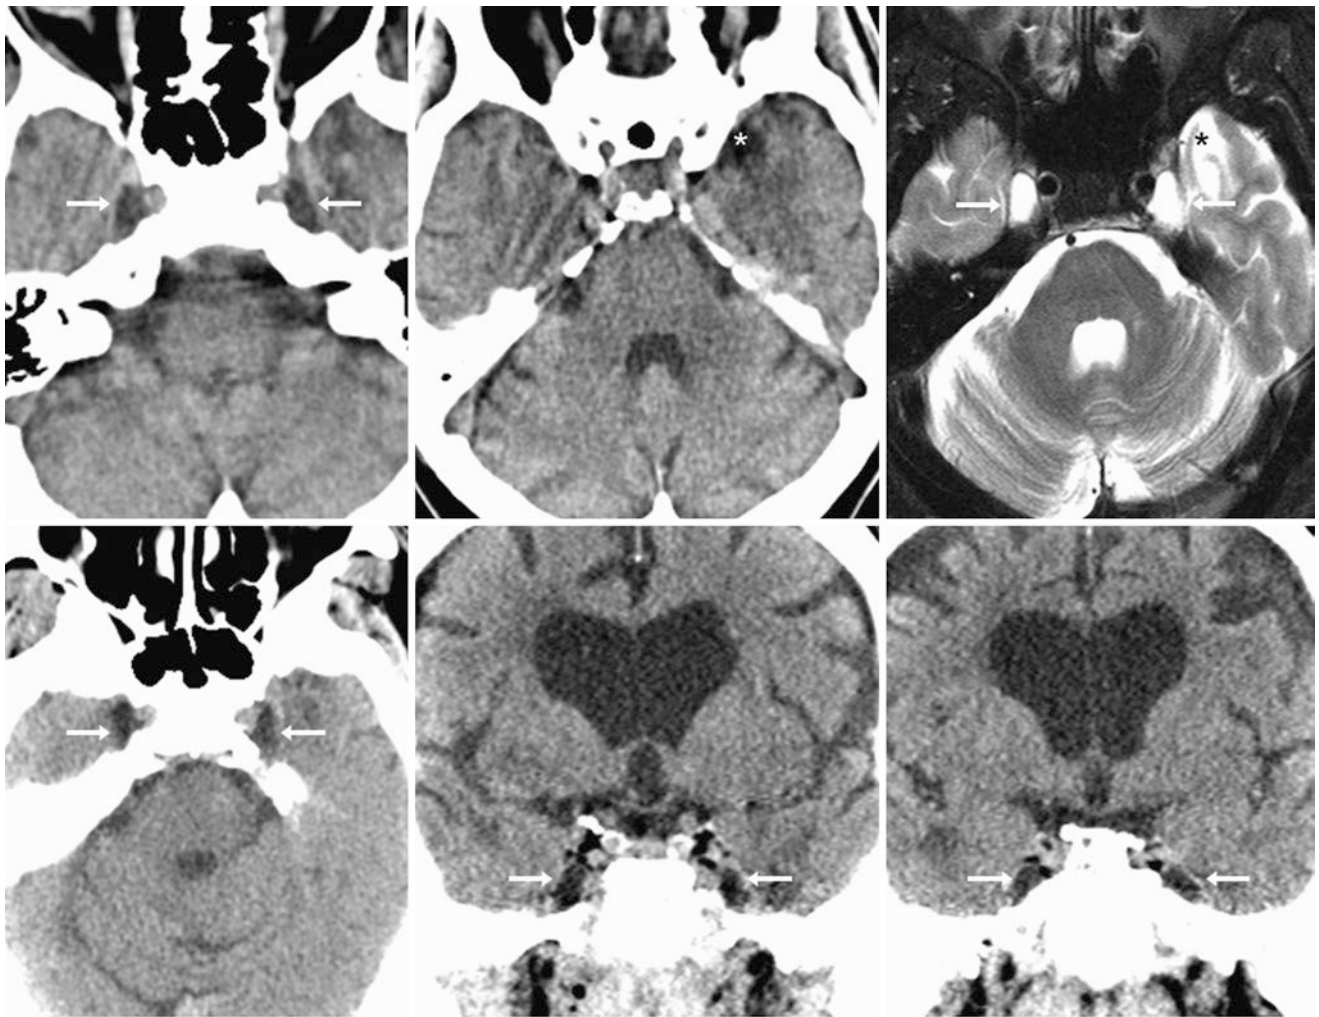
A 69-year-old patient with trauma; there are moderately prominent Meckel caves (arrows) bilaterally on axial NECT (top left and top middle). Note the left anterior temporal encephalomalacia (*). On a 1.5 T MRI at that time with T2WI (top right), these are confirmed to be Meckel caves. A repeat NECT 10 year later (bottom left) with coronal reconstructions (bottom middle and bottom right) demonstrated no significant change in their size
